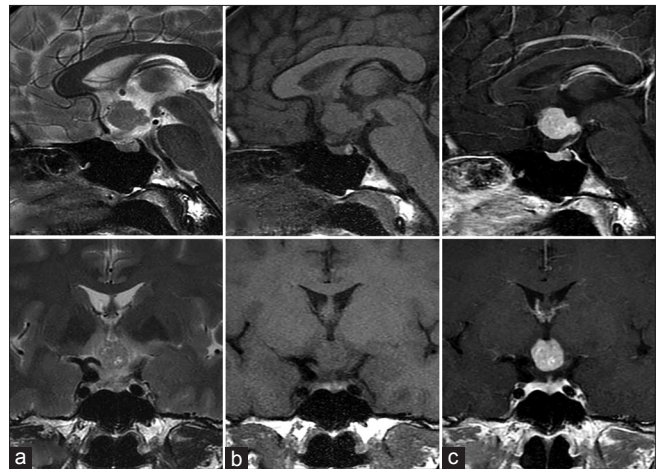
Preoperative T2-weighted (a), T1-weighted (b), and gadolinium-enhanced T1-weighted (c) magnetic resonance imaging (MRI) shows a tumor mass in the suprasellar region. The tumor shows a high level of homogeneous enhancement with gadolinium
